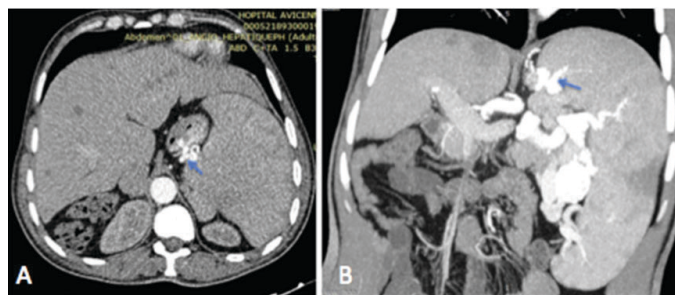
Axial CTA (A) and coronal reconstruction and maximum intensity projection (MIP) (B) at arterial phase showing a vascular malformation supplied by splenic arteries (arrow) with dilatation and tortuosity of the splenic artery, which expanded into an aneurysm.
